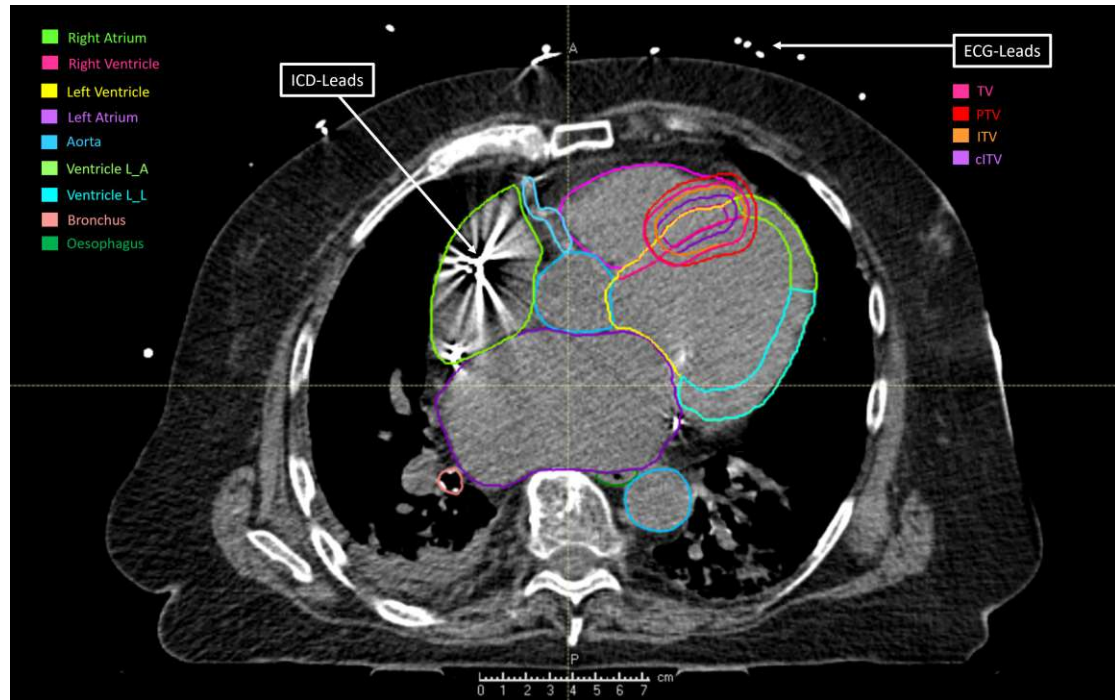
Example of a planning CT (axial plane) with the contours drawn by the medical doctors participating in the RAVENTA study in Germany. Here it is possible to observe the different cardiac structures (atria, ventricles, and ventricle walls), some OARs (bronchus and oesophagus), target delineations (TV, PTV, ITV, CITV), and the internal ICD leads causing major artefacts in the image.
